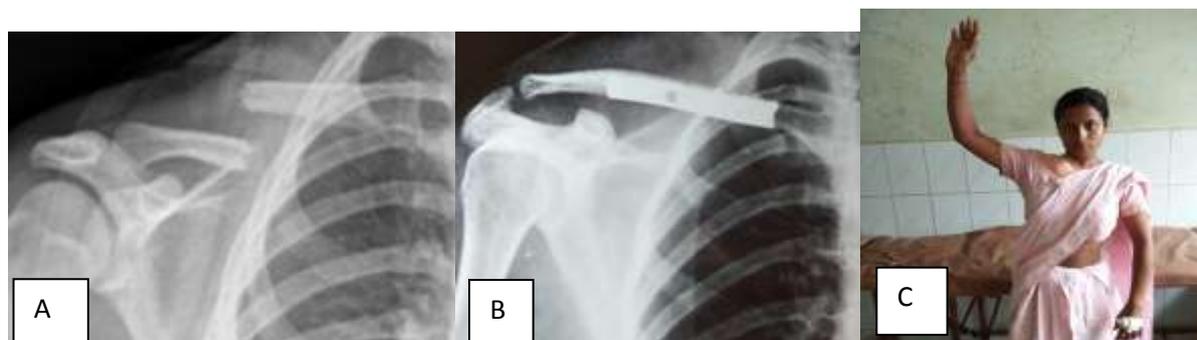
A. preoperative x-ray B. immediate post-operative x-ray C. clinical pics showing full range of motion(2wks post op)
